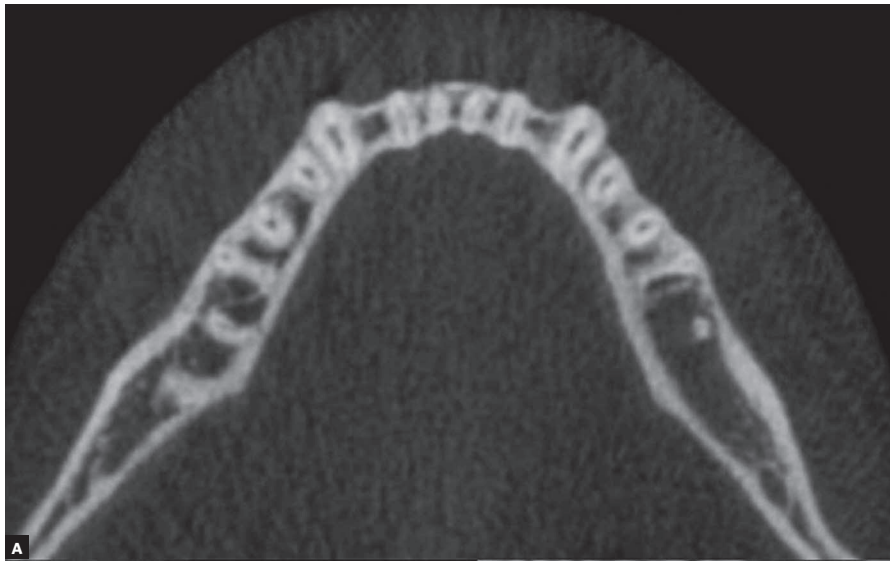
CBCT (September/2016). (A) axial image. (B) axial image, no evidence of external cortical bone disruption; lesion dimension; (C) sagittal image.
